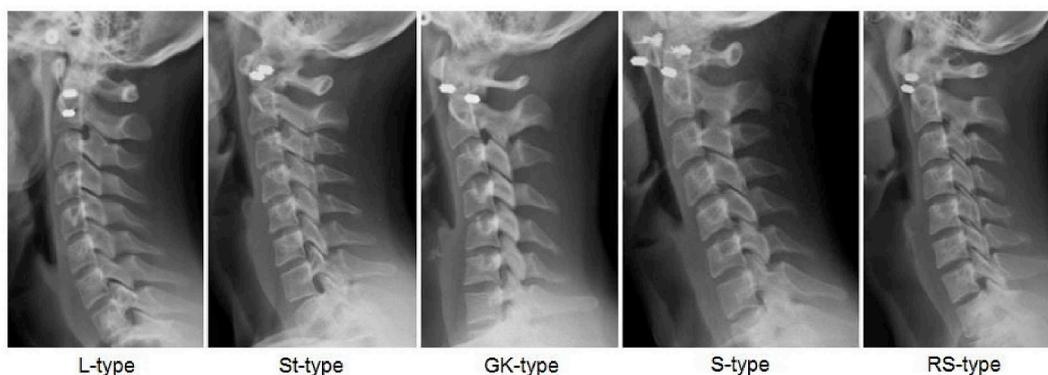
A radiographic representation of the typical alignment patterns observed within each cervical subtype classification: Lordotic (L-type), Straight (St-type), Global Kyphotic (GK-type), Sigmoidal (S-type), and Reverse Sigmoidal (RS-type) subtypes.
